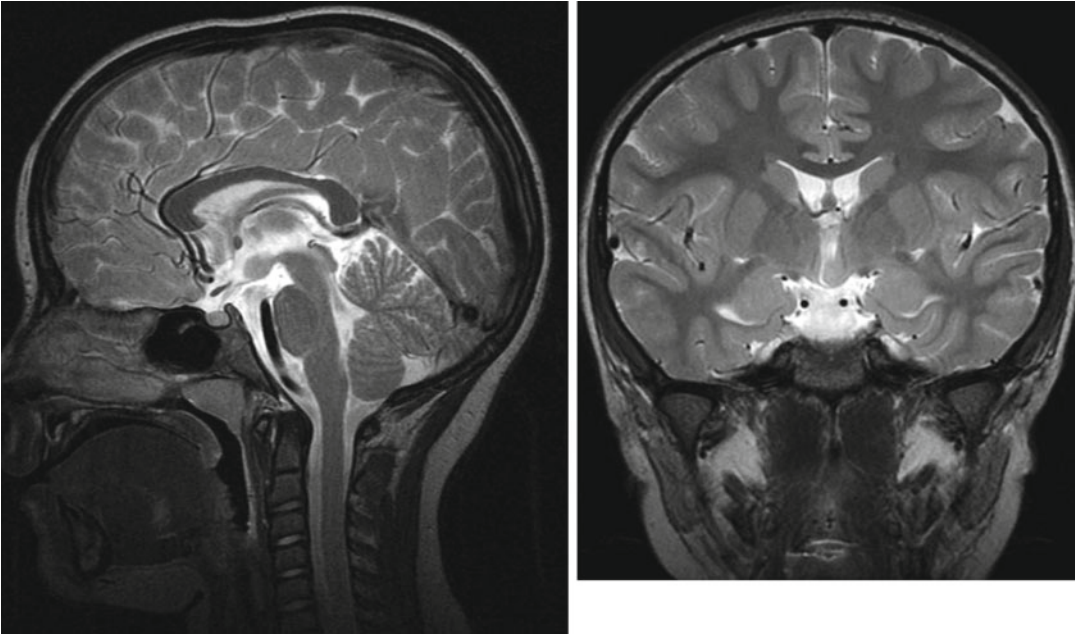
Example of a small type II hamartoma suitable for endoscopic treatment. T-2-weighted sagittal (*left*) and coronal (*right*) MR images showing a hypothalamic
